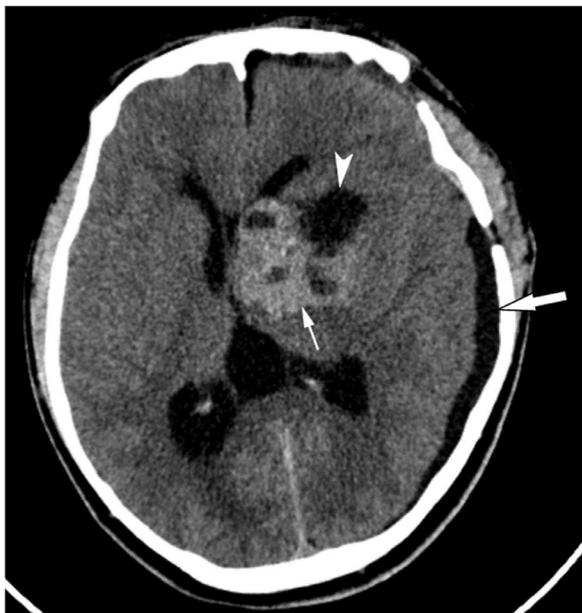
Case 1: Postoperative computed tomography (CT) image after 2 weeks demonstrated a heterogeneous mass in the basal ganglia and thalamic region, extending into the left lateral ventricle (small arrow), a cavity in the brain tissue (arrowhead), and subdural fluid collection (large arrow).
